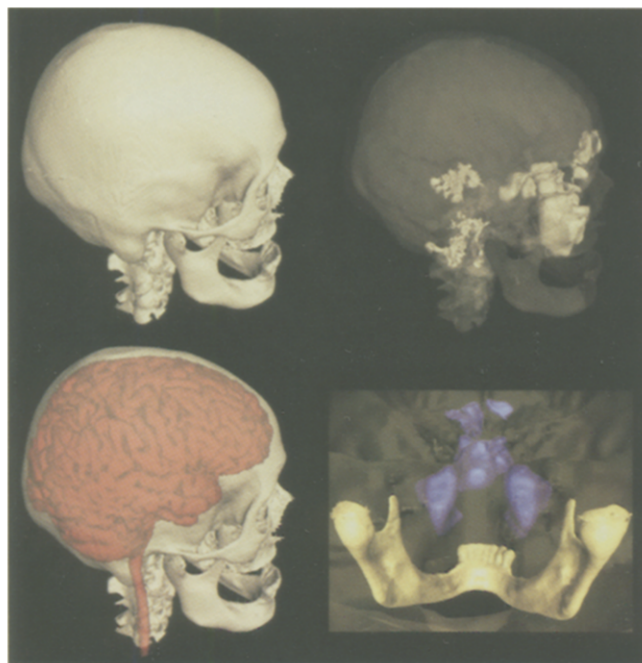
3D segmentation and volume rendering from registered CT and MRI data.
